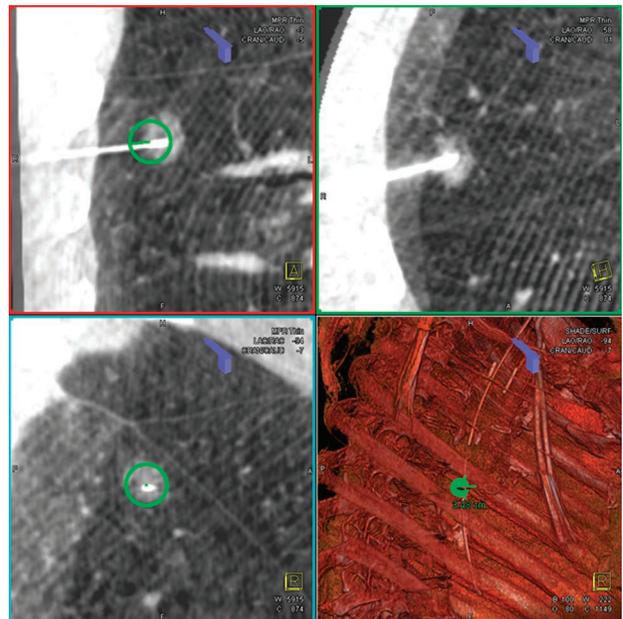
Intraoperative computed tomography guided needle placement inside the mass.
